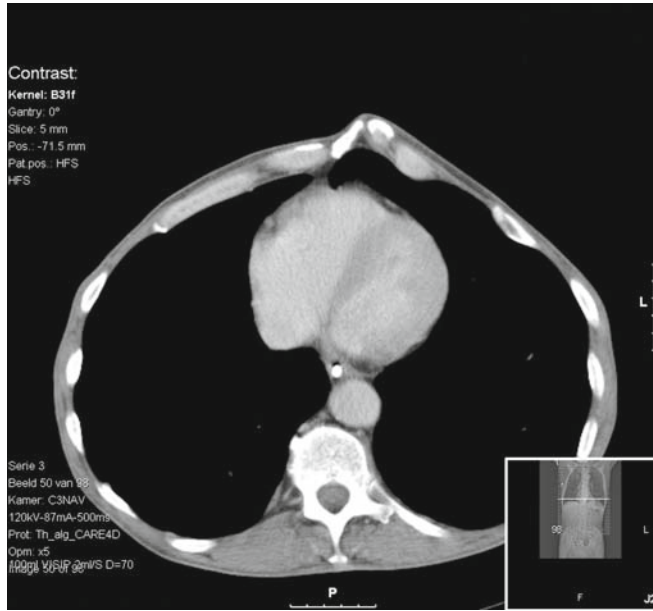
Chest computed tomography (CT) scan: performed 4 months after the diagnosis of esophageal carcinoma, to evaluate the response of the esophageal mass to radiation therapy. At that time, the CT scan of the heart was unremarkable
